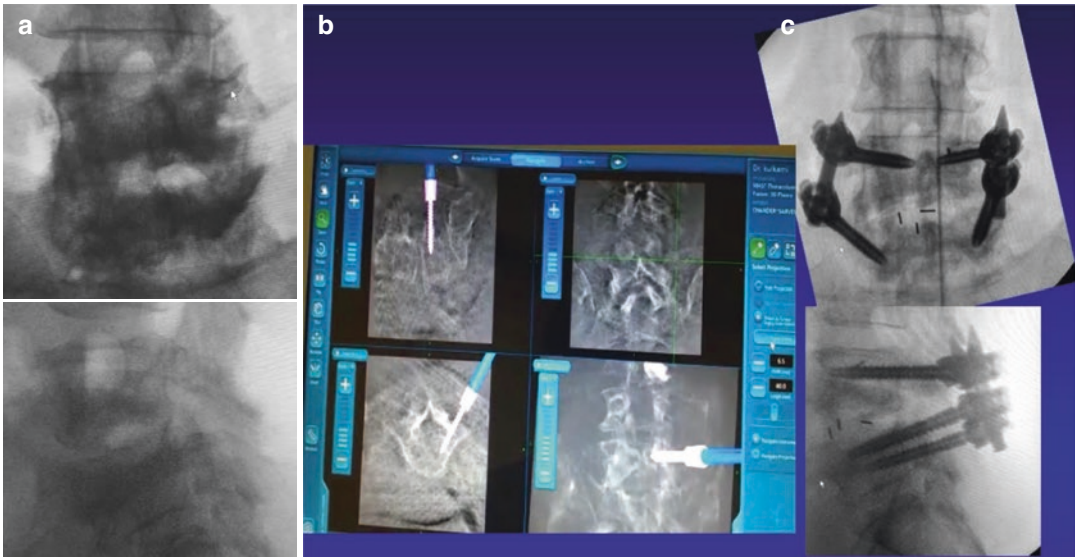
(a) Poorly defined anatomy on 2D fluoroscopy images. (b) Pedicle screw insertion using 3D navigation. (c) Post operative X-ray of MI-TLIF
